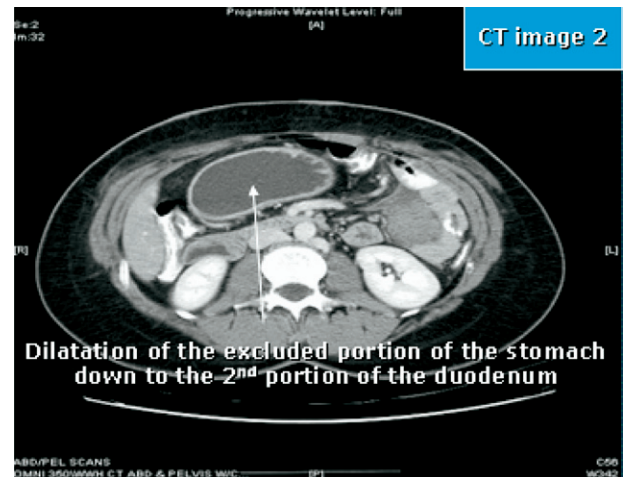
Computed tomography (CT) scan showing dilation of excluded portion of stomach down to second portion of duodendum.
